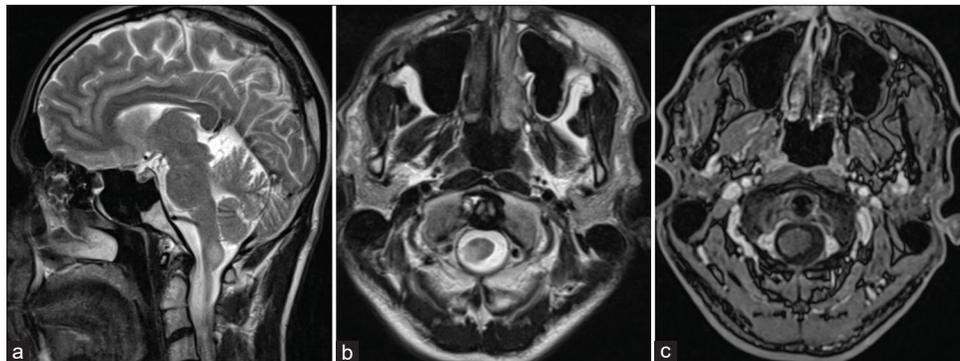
Preoperative MRI. (a) T2-weighted image, sagittal plane. Tumor of 14 × 10 × 6 mm in size in the caudal dorsal medulla and upper cervical cord (hypertensive signal). (b) T2-weighted image, axial plane. The tumor on the right side of the medulla has similar characteristics. (c) Contrast enhancement axial T1. No contrast enhancement in this lesion.
